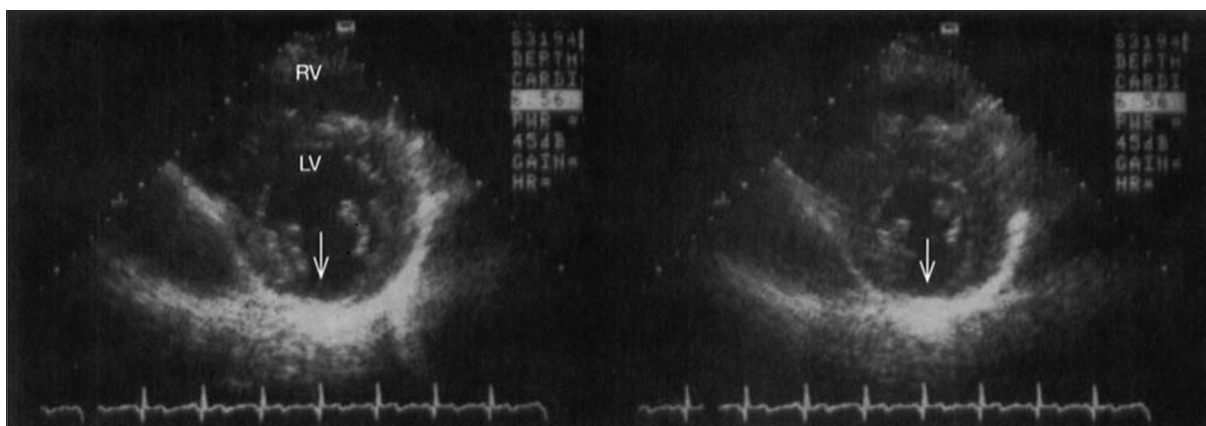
Parasternal short-axis view of the left ventricle (LV) at the level of the papillary muscles in a patient with an old inferior myocardial infarction (MI). The left panel was recorded at end-diastole and the right panel was recorded at end-systole. Thinning and lack of motion in the inferior wall can be noted (arrows).
